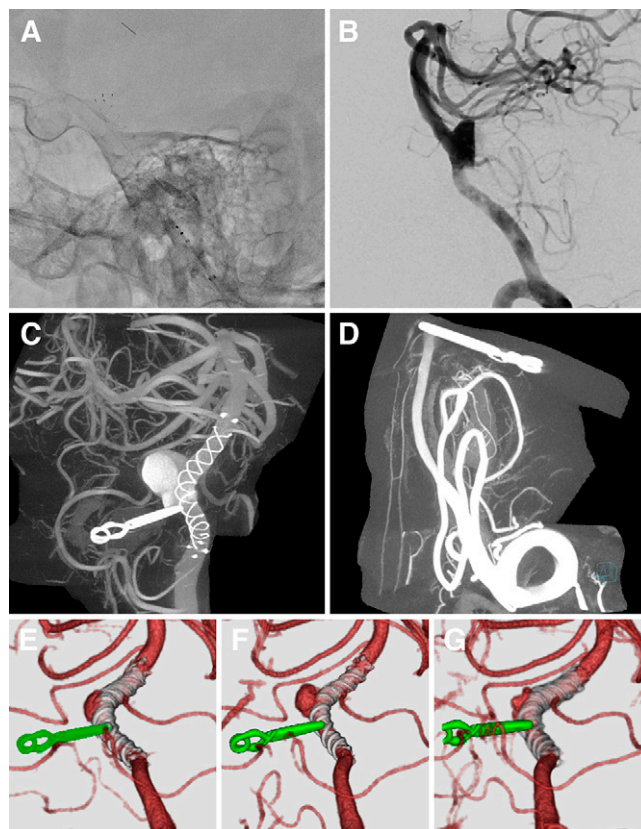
A: Postplacement lateral fluoroscopy images of the FD. B: Lateral DSA indicates that blood is stagnant within the aneurysm fundus. C: Cone beam CT confirms appropriate placement of the FD. D: Cone beam CT demonstrates preservation of the ASA proximal to the clip. E: CTA at 6 months post-FD placement shows obliteration at OKM grade C. F: CTA at 12 months post-FD placement reveals a worsened occlusion status at OKM grade B. G: CTA at 18 months post-FD placement indicates an improvement in occlusion status to OKM grade C.
